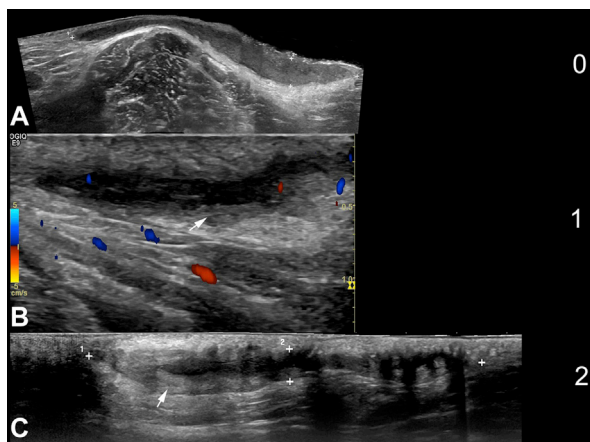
Hidradenitis suppurativa (HS). Grading of fibrotic scarring in HS fistulous tracts. Longitudinal axes of fistulae (A and C, grey scale ultrasound; B, color Doppler ultrasound) demonstrates the grades of fibrotic scarring (*white arrows*). Notice the increased vascularity (colors) in the periphery of the fistula in (B). +, Markers of the borders of the fistulous tracts in A and C.
